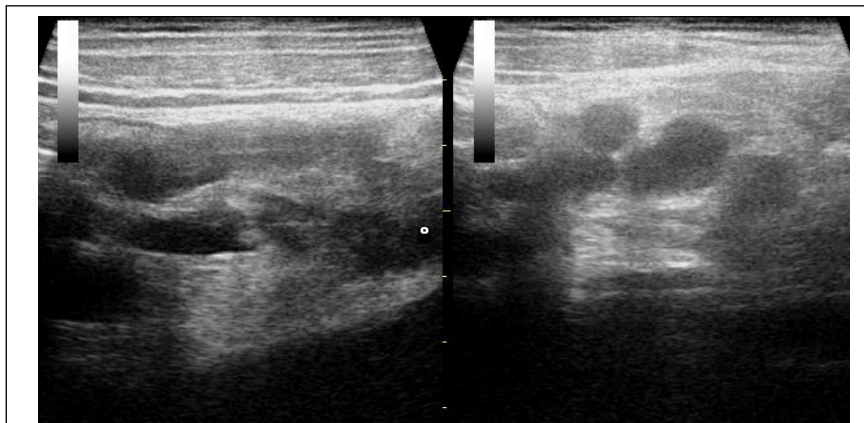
High frequency sonography shows ileocaecal region tuberculosis show thickening of terminal ileum and caecum. Multiple enlarged lymph nodes are seen in RIF.
